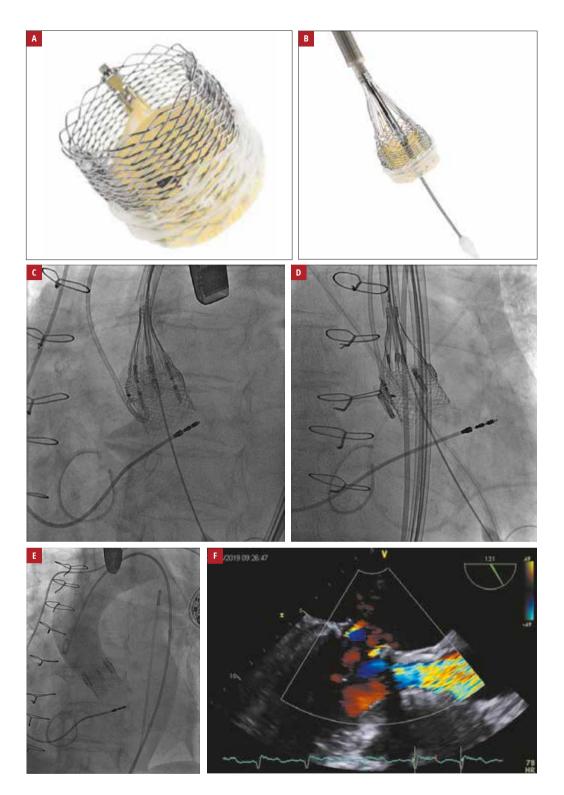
A – Lotus Edge valve; B – Lotus Edge valve attached to the delivery system; C – angiogram from the procedure showing the valve just before the final locking; D – angiogram from the procedure showing the valve after release; E – angiogram at the end of the procedure—no leak around the device; F – final transesophageal echocardiography showing good function of the transcatheter aortic valve and mitral valve bioprosthesis; A and B – reproduced with permission from Boston Scientific (Marlborough, United States)
